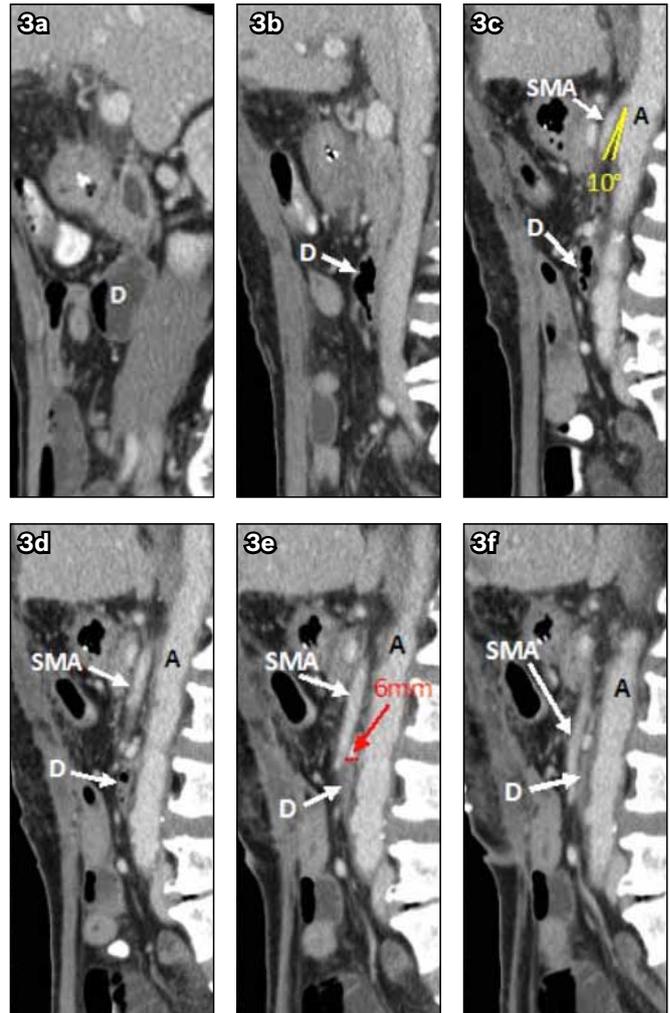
Sagittal cuts of the CT of the abdomen from right to left show (a) a dilated D2/3 junction to the right of the SMA; (b) the beginning of narrowing in D3; (c) SMA takeoff from the aorta with a reduced aortomesenteric angle (yellow) of 10°; and (d-f) a reduced aortomesenteric distance (red) to 6 mm.
